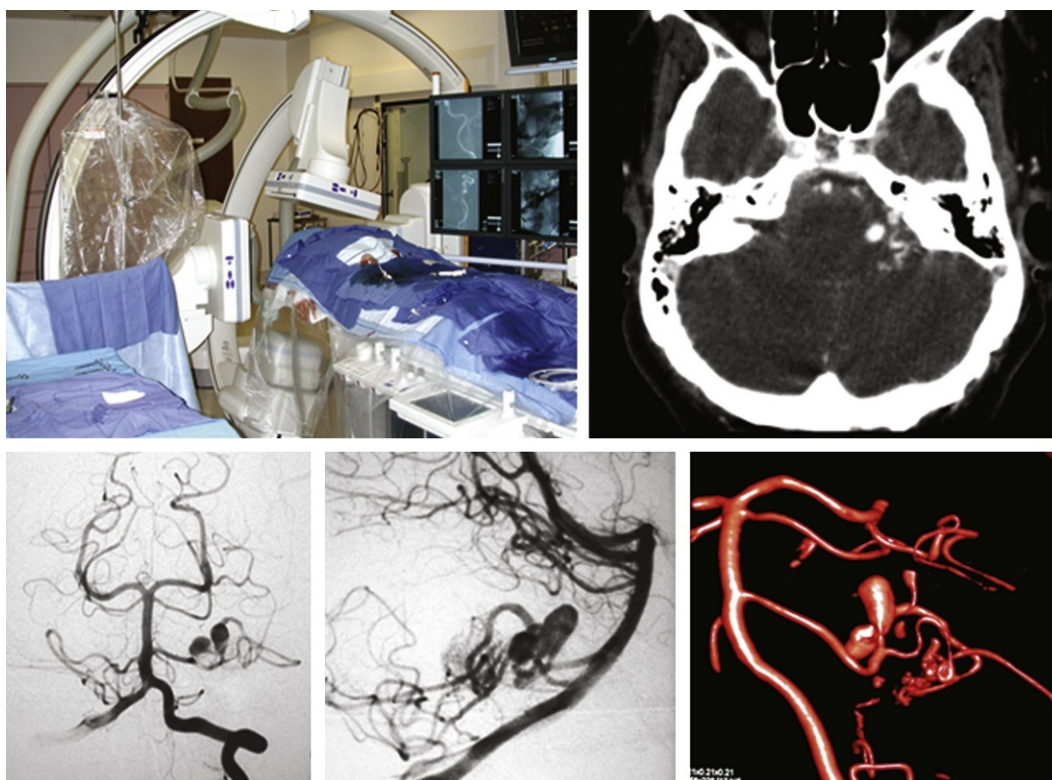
State-of-the-art neuroangiography suite (top left) has the capability to perform computed tomography (top right), biplane angiography (bottom left and middle), and three-dimensional reconstructed rotational angiography (bottom right). These views show a small cerebellar arteriovenous malformation with recently ruptured feeding artery aneurysms (see Fig. 14.6).
